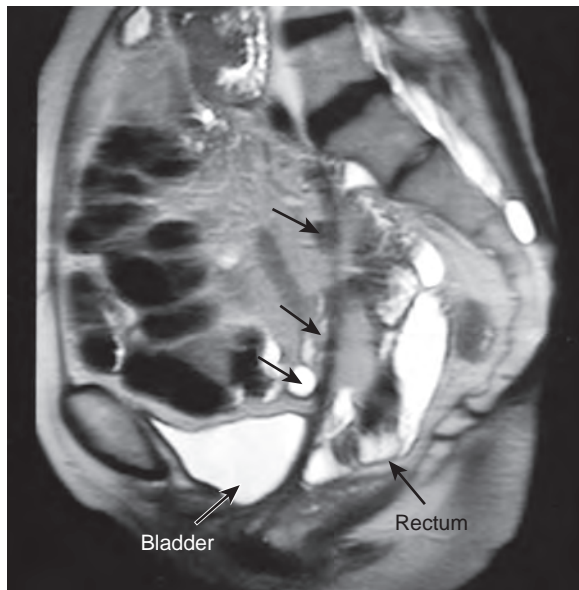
Magnetic resonance imaging identifies mesh (arrows) in a patient with pain after sacrocolpopexy.
